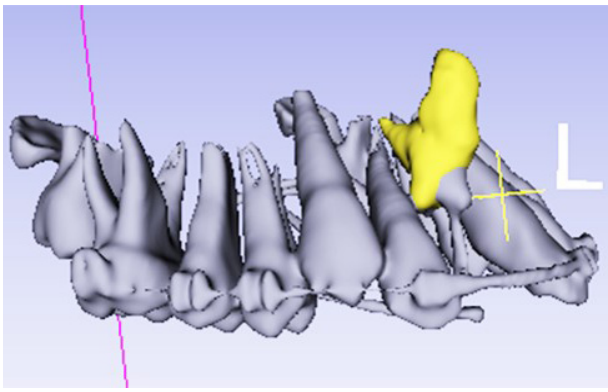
CBCT based 3D surface rendering after segmentation of the upper arch giving a better visibility of location and anatomy of the impacted incisor.
